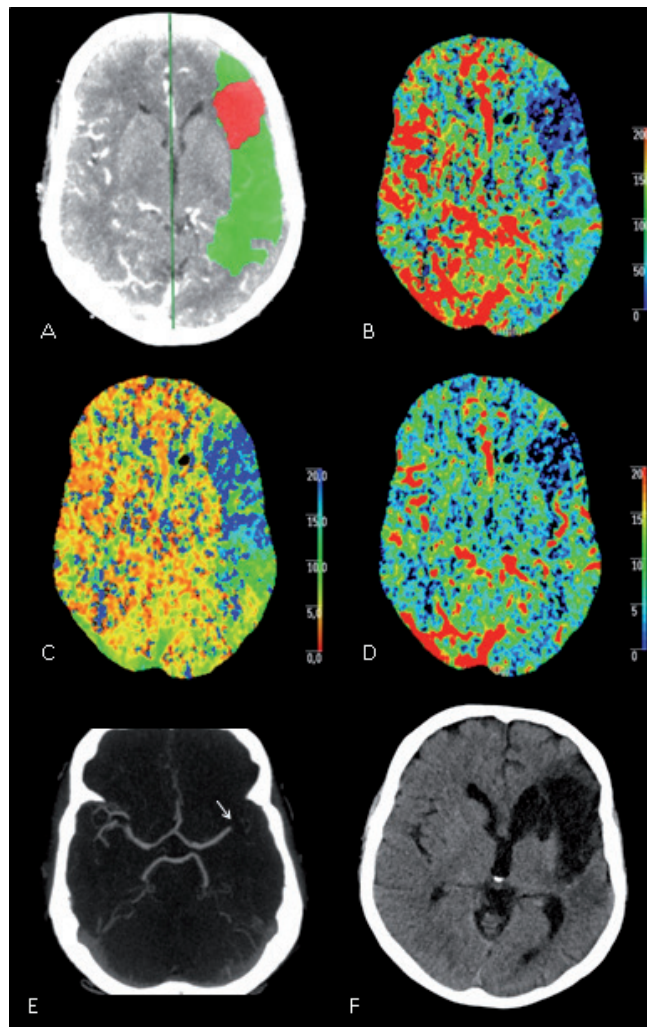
Perfusion CT in acute ischemic stroke.
